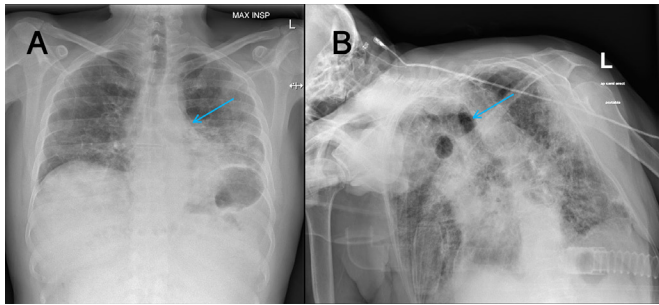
Chest radiographs, pneumomediastinum indicated by arrows. (A) Patient 1 and (B) patient 2 showing worsening bilateral infiltrates and pneumomediastinum with no evidence of obvious pneumothorax.
